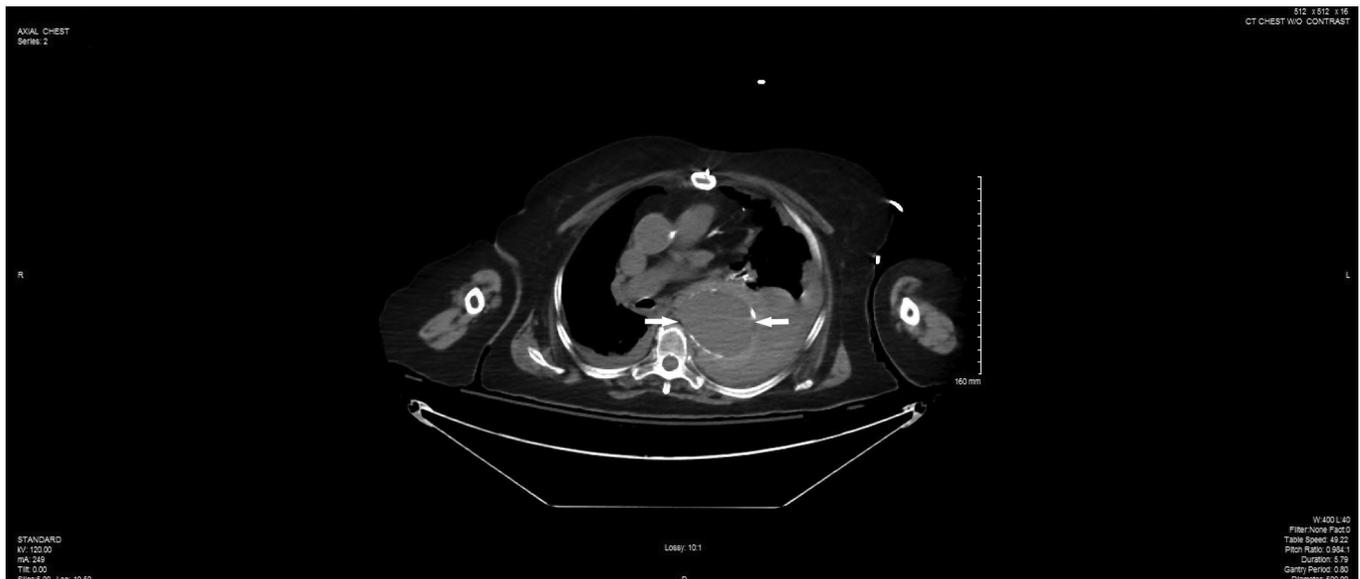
Non-contrast CT scan of chest (distal window).
